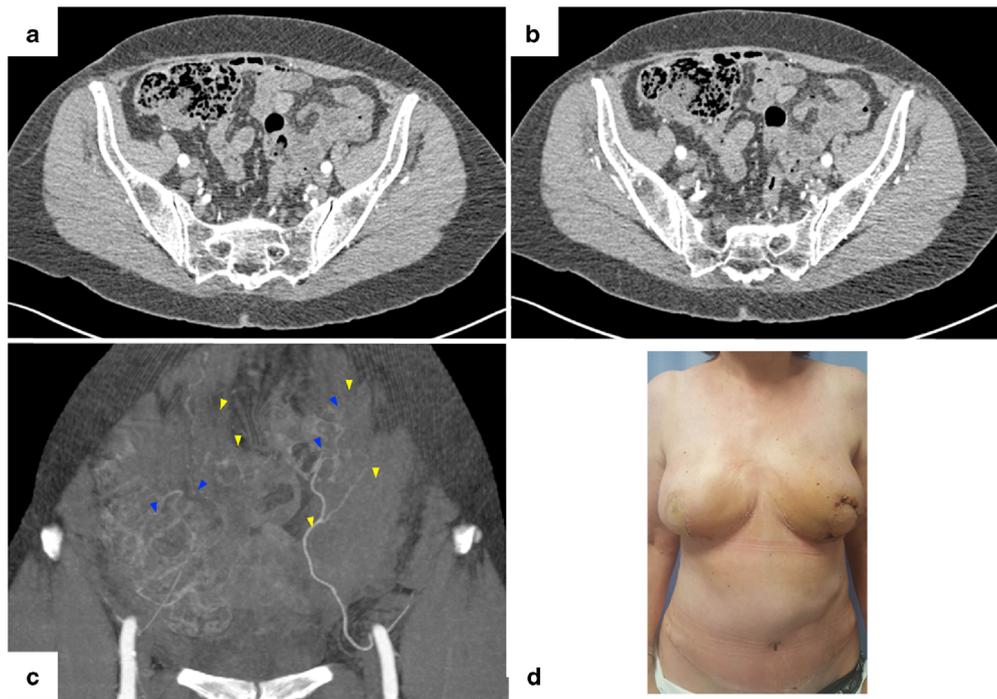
Axial CTA of case 2 (a, b) demonstrating a large left-sided DIEA and a small right-sided DIEA. Coronal maximal intensive projection (MIP) of CTA (c, blue arrows are large perforators; yellow arrows are
